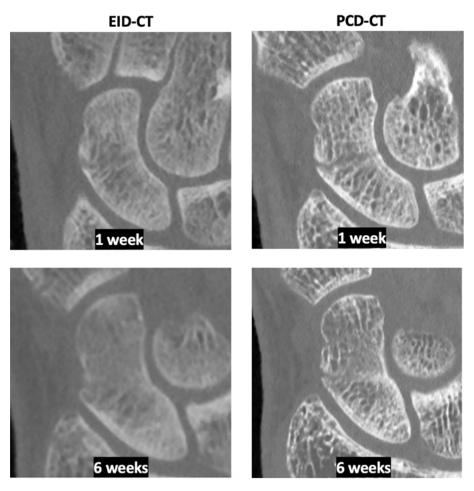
Wrist scaphoid fracture scanned using EID-CT (left) and PCD-CT (right) at 1 day and 6 weeks after injury. Note the better visibility of the fracture line and the trabecular structure on the inside of the bone.
